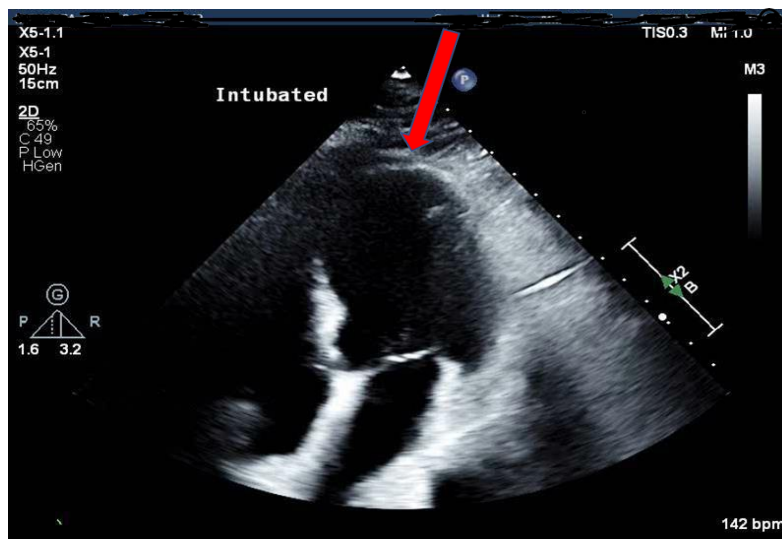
Transthoracic echocardiogram showing ballooning of the Left Ventricle.
